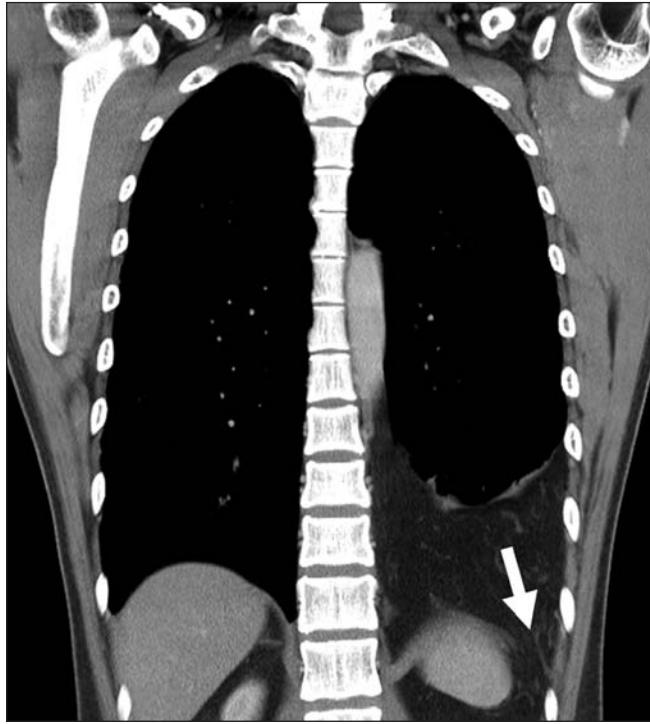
Computed tomography scan (coronal section) of the chest in a 36-year-old man showing a prominent peritoneal fat herniation through a left posterolateral diaphragmatic defect (arrow), with no evidence of pleural fluid collection.
